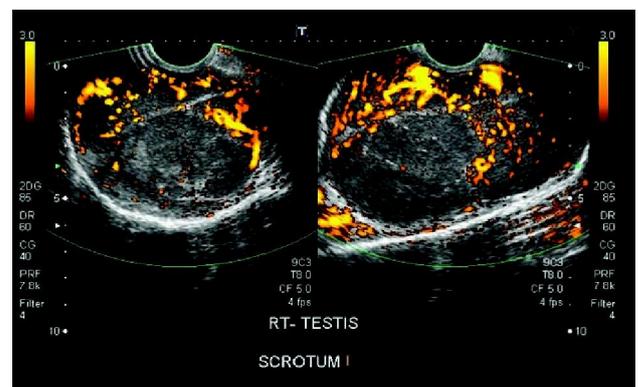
Color Doppler showing increased flow in right testis.
